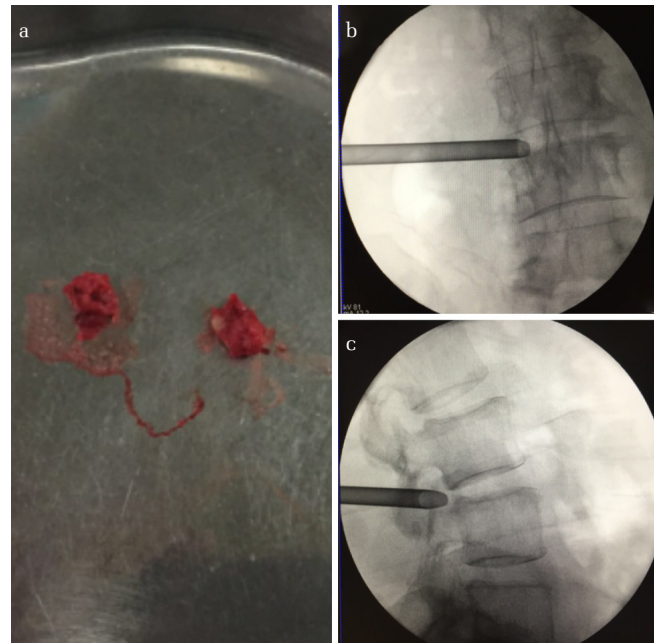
a-c. a. The two segments of bone are removed by two foraminoplasty procedures. b. Posterior-anterior (AP) X-ray, showing placement of the working sheath (transforaminal approach). c. Lateral X-ray showing placement of the working sheath (transforaminal approach). The bevel of the working sheath is located in the intraspinal canals completely in the lateral fluoroscopic view
